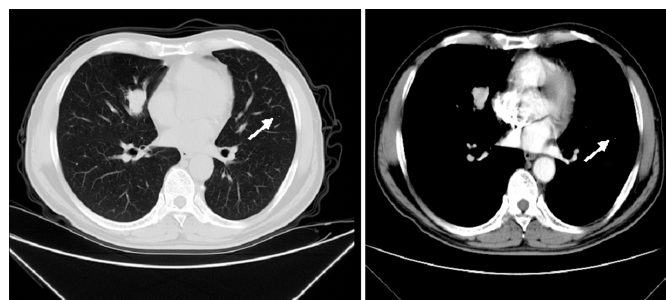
Contrast-enhanced CT of the chest revealed a mass in the right middlelung.
